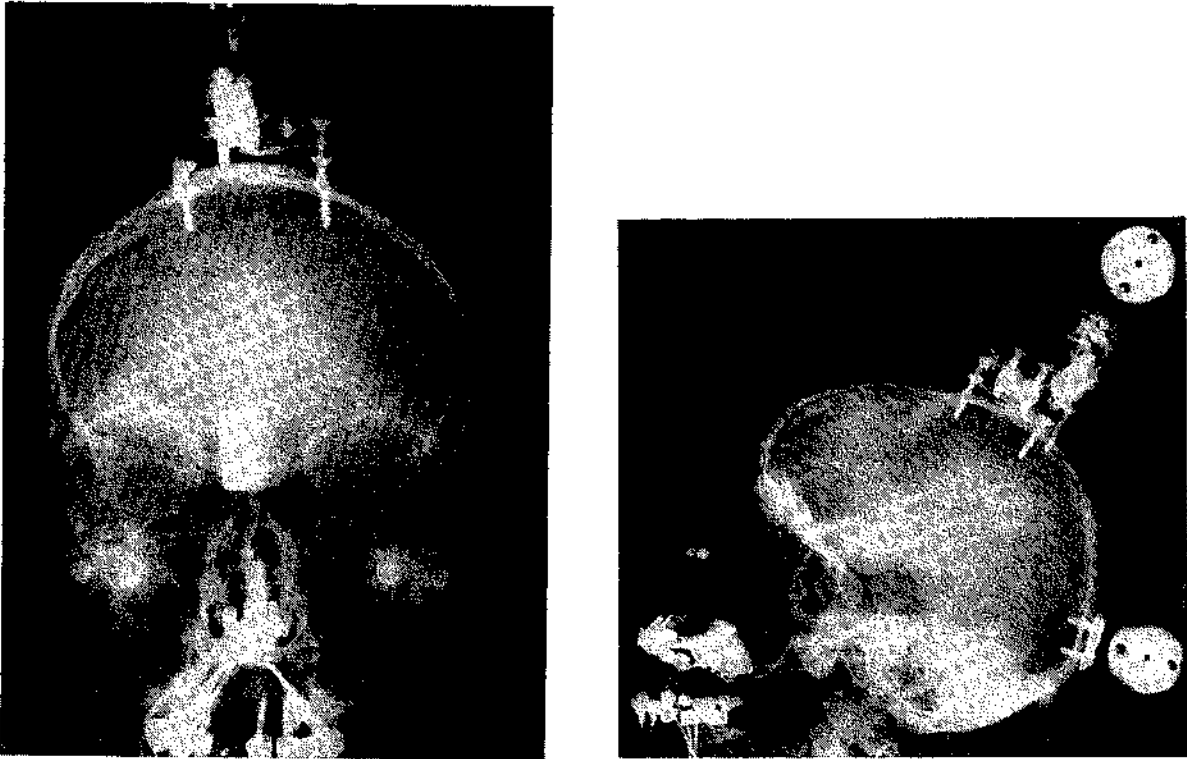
Anterior-posterior and lateral x-rays with head instrumentation.
